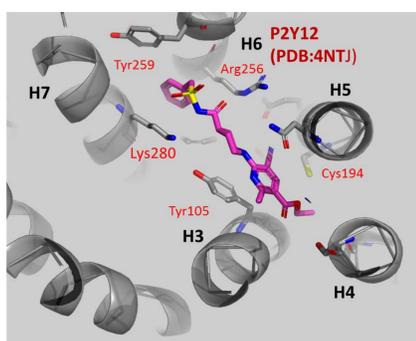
X-ray structure of AZ1283 in P2Y₁₂ (PDB:4NTJ). The X-ray structure of AstraZeneca compound AZ1283 shows H6 displacement outward to accommodate benzyl-acyl-sulfonamide moiety. Key interactions other than polar acid (bioisostere) to basic residues are two key π face interactions with Tyr105 and Tyr259.
